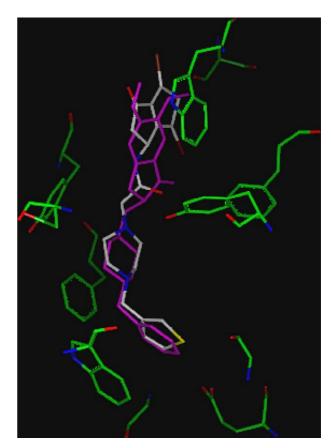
The stick representation of the binding site of AChE (green) and donepezil (purple) from X-ray structure, with the modeled position of compound 43 (gray).
